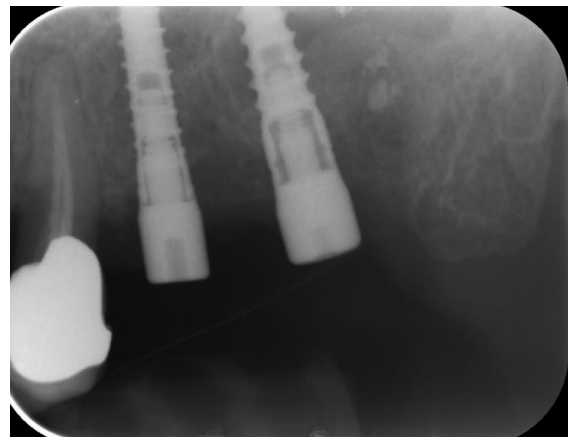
An X-ray was carried out after 3 months.*
